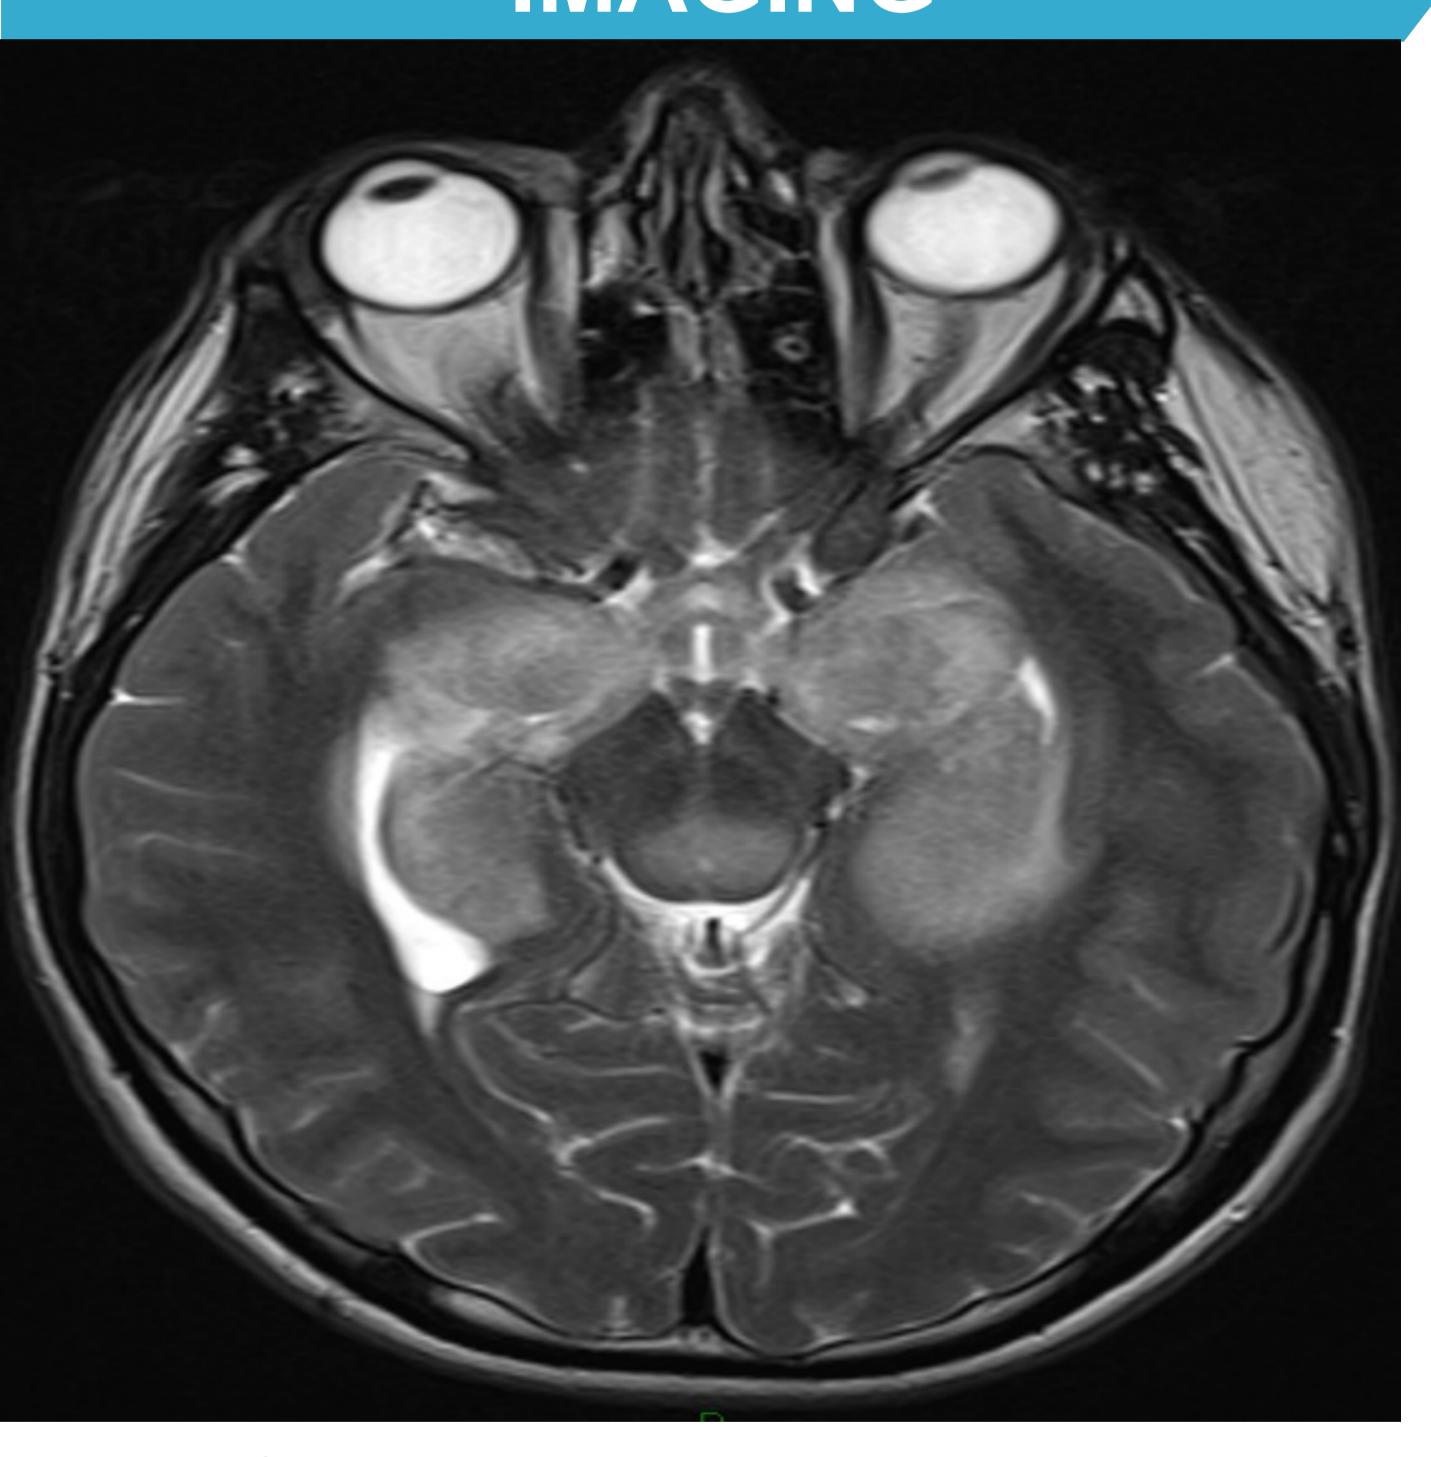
Initial MRI scan – August 2021
